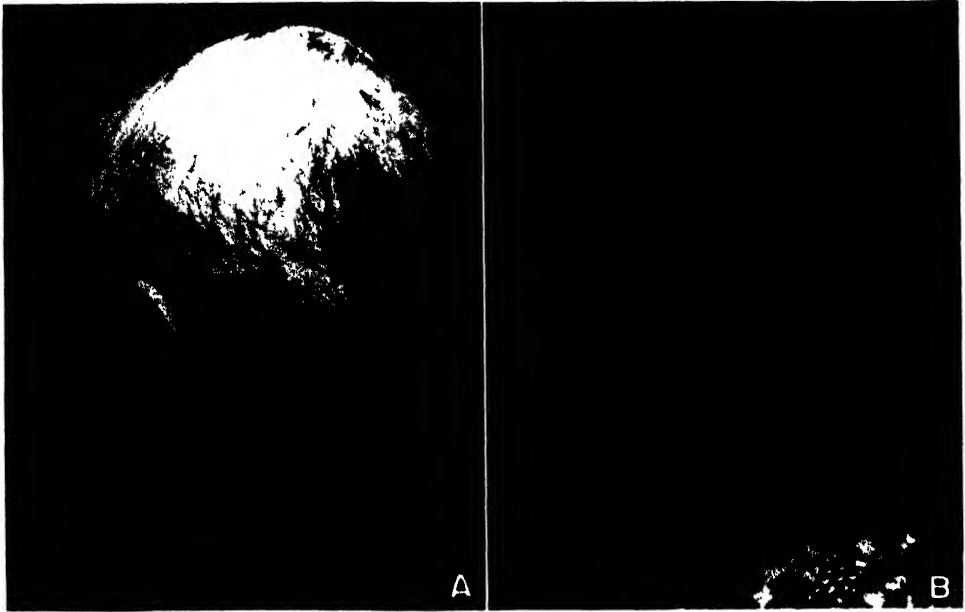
Tinea capitis in an adult, showing results of x-ray therapy. *A*, 10 weeks after administration of epilating dose. *B*, six weeks later, showing uniform return of hair. Length from scalp is approximately 1.6 cm.
